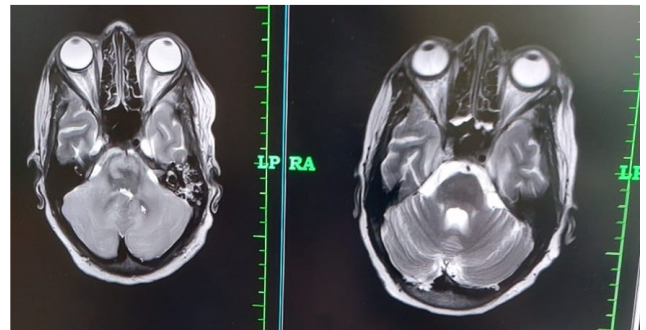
MRI brain repeated on 19th day of illness
